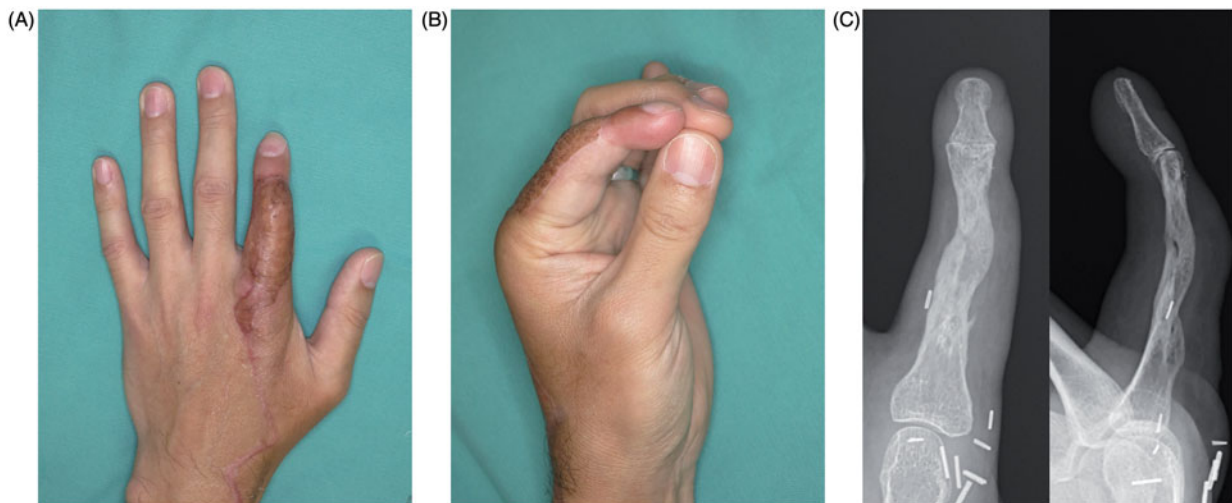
Appearance of case 2 at 7 months postoperatively. (A) General view of the left hand. The reconstructed finger has atrophied. (B) Shortening of the index finger allows tripod pinch. (C) X-ray revealing union of grafted bone.
